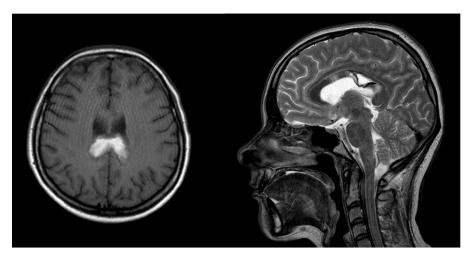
MRI brain done after three month from the impact.
